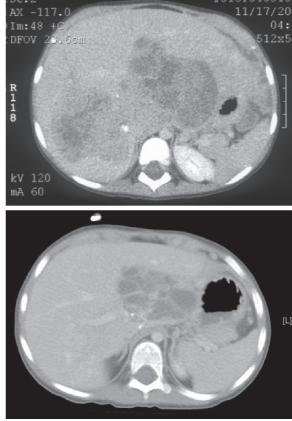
Typical response of hepatoblastoma to neoadjuvant chemotherapy. CT findings at diagnosis in a child with hepatoblastoma. The tumor involves both right and left hepatic lobes and is inoperable. CT scan in the same child following four cycles of chemotherapy. The tumor is confined to left lobe and is eminently resectable.
